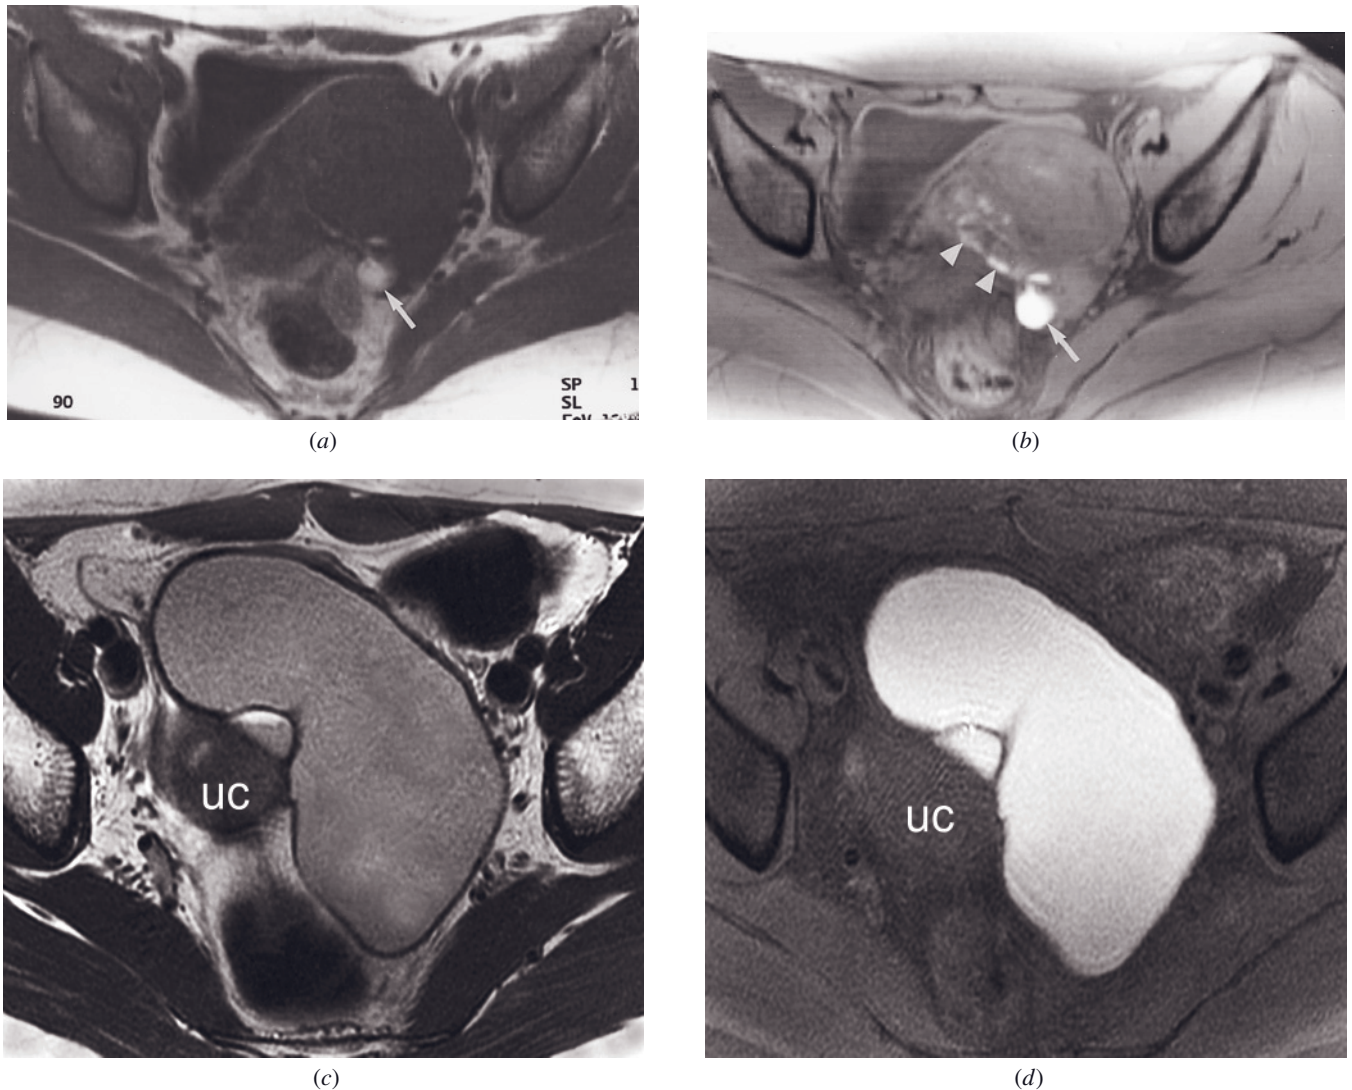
Endometriosis: benefit of fat-suppression. T1-weighted SE (a) and T1-weighted fat-suppressed gradient-echo (b) images in a patient with bilateral adnexal masses shown on transvaginal ultrasound. There is a high-signal-intensity mass applied to the left ovary on the T1-weighted image (arrow, a), which is more conspicuous on the fat-suppressed image (arrow, b). Note that the small endometrial implants applied to the uterine serosa are well seen with the fat suppression technique (arrowheads, b). Large endometrioma at 3 T. Transverse T2-weighted ETSE (c) and T1-weighted fat-suppressed T1-weighted gradient-echo (d) images in a different patient show a large endometrioma with a single septation adjacent to the uterine cervix (uc). In this case, no additional small implants were seen on fat-suppressed images.
